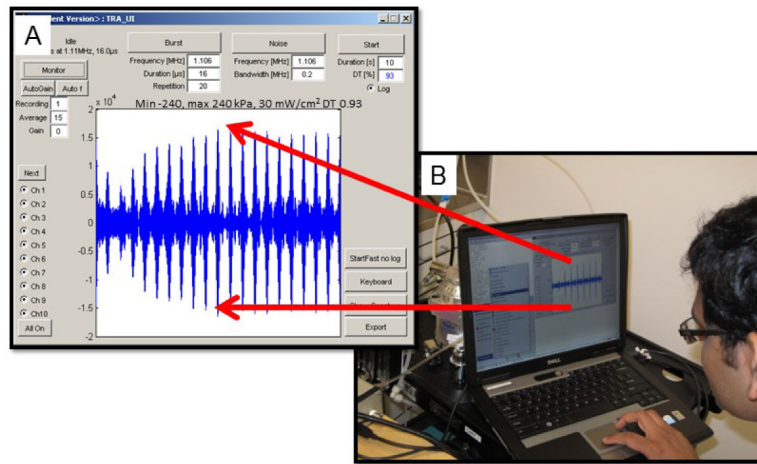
TRA-UCED MatLab® interface and user control center. A. Screen shot of graphical user interface and focusing of multiple ± 240 kPa 1.1 MHz ultrasonic pressure waves to the smart needle. B. PC-based computer running the TRA-UCED system in the laboratory.
